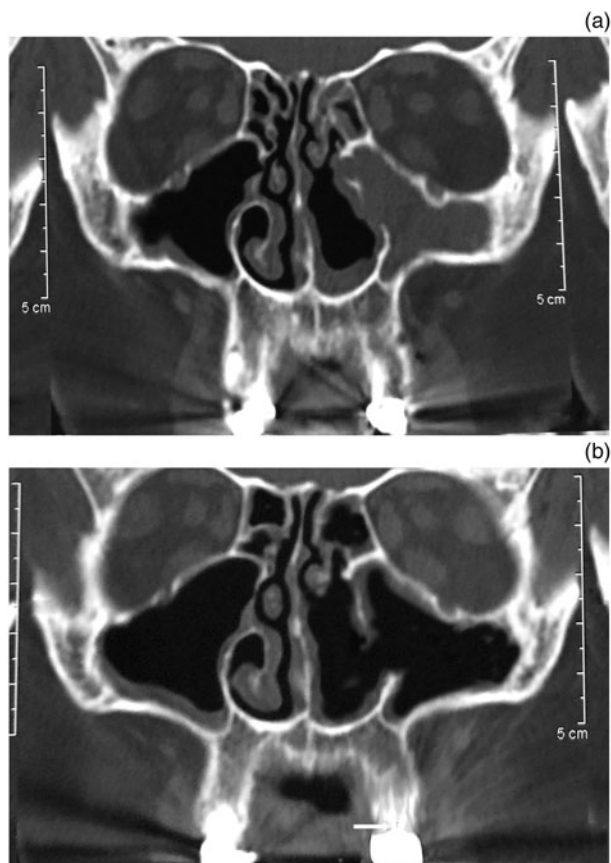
Coronal computed tomography scans of: (a) a patient who was treated surgically three times for his left maxillary sinusitis without resolution of the infection; and (b) the same patient after successful endodontic treatment (white arrow), showing complete resolution of the infection with no need for further endoscopic sinus surgery.
